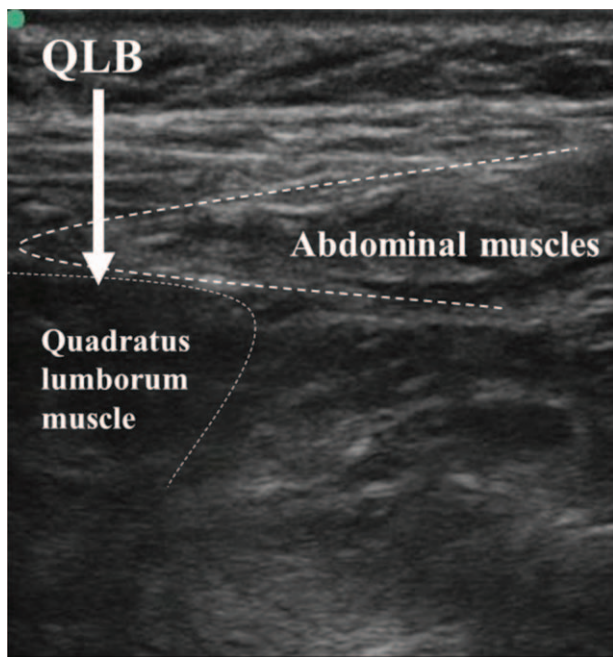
Ultrasound view of the quadratus lumborum muscle. Abdominal muscles seen may include the transversus abdominis and internal oblique muscles. The arrow indicates the direction of the quadratus lumborum block. The injection point for the quadratus lumborum block is on the posterior aspect of the quadratus lumborum muscle.
